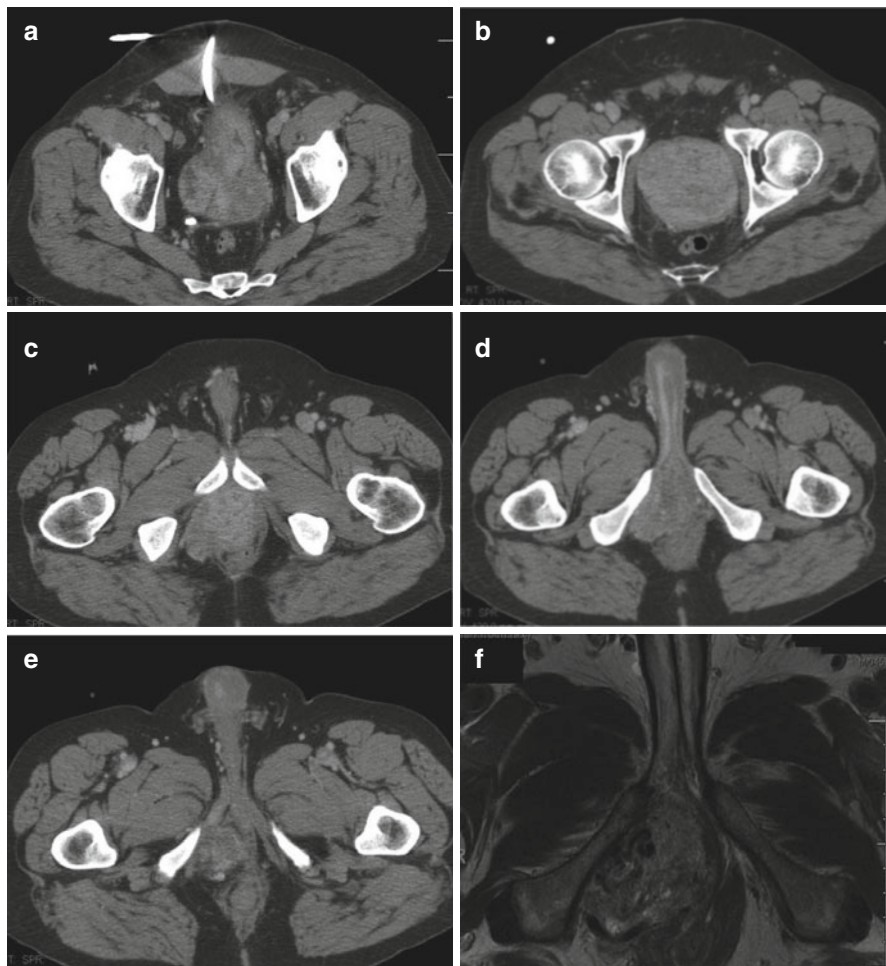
A 45-year-old male presented with urinary obstruction and was found to have a large prostate stromal sarcoma. (a–e) Axial computed tomography images. Note suprapubic tube and involvement of bladder and right pelvic sidewall structures. (f) Axial T2 magnetic resonance images demonstrating right pelvic sidewall involvement. The patient was treated with preoperative doxorubicin and ifosfamide, prior to a planned radical cystoprostatectomy
